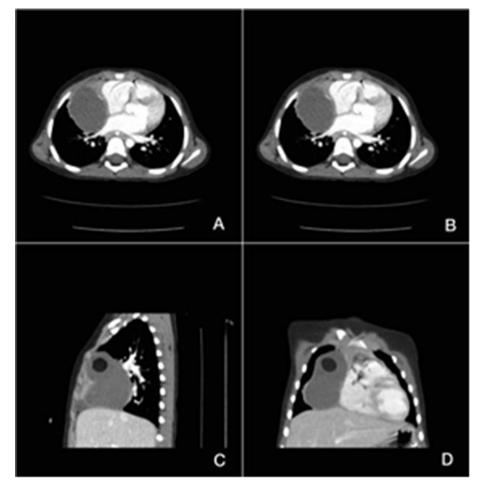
CT scan showed a well-defined large cystic mass lesion noted at the right anterior mediastinum (A) and an anterior cystic mediastinal mass with a fatty component (B, C, D).
